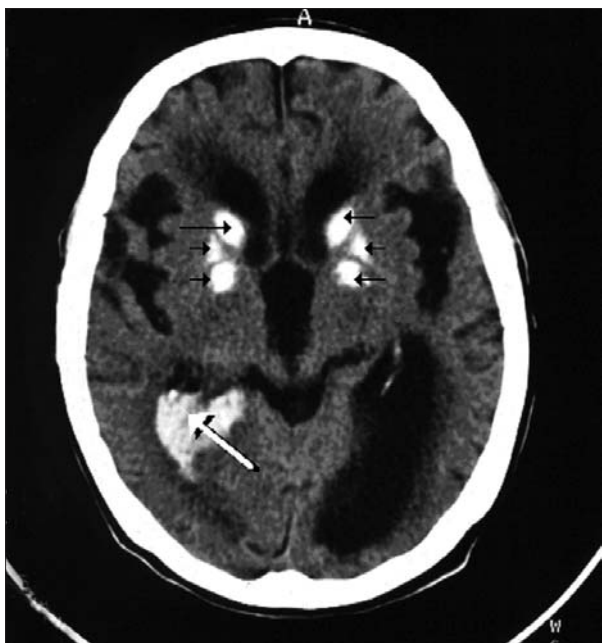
CT scan showed an occipital hemorrhage with ventricular contamination (large white arrow), but also a diffuse cerebral atrophy with enlargement of the ventricles, and basal ganglia calcifications (small black arrows).
